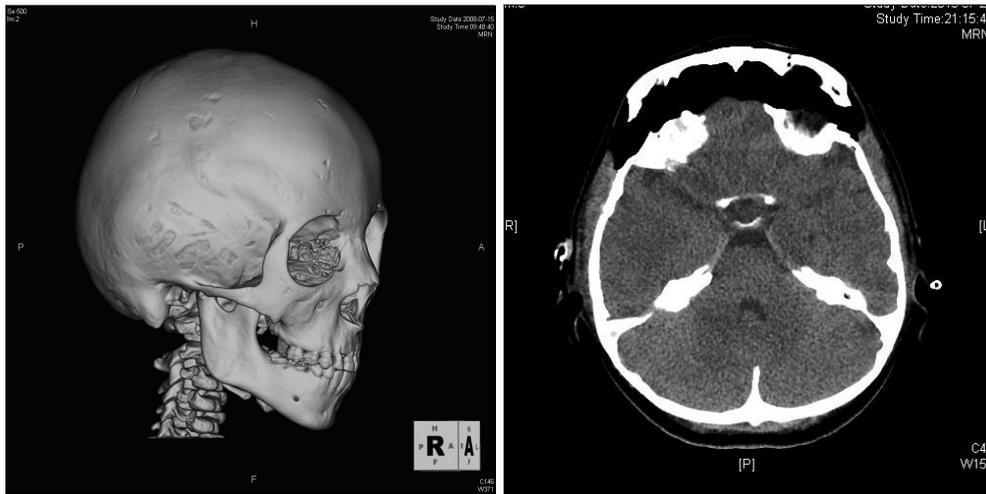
Computed tomography images of the patient. (Left) Preoperative 3-dimensional image. (Right) Image of postoperative day 1.
